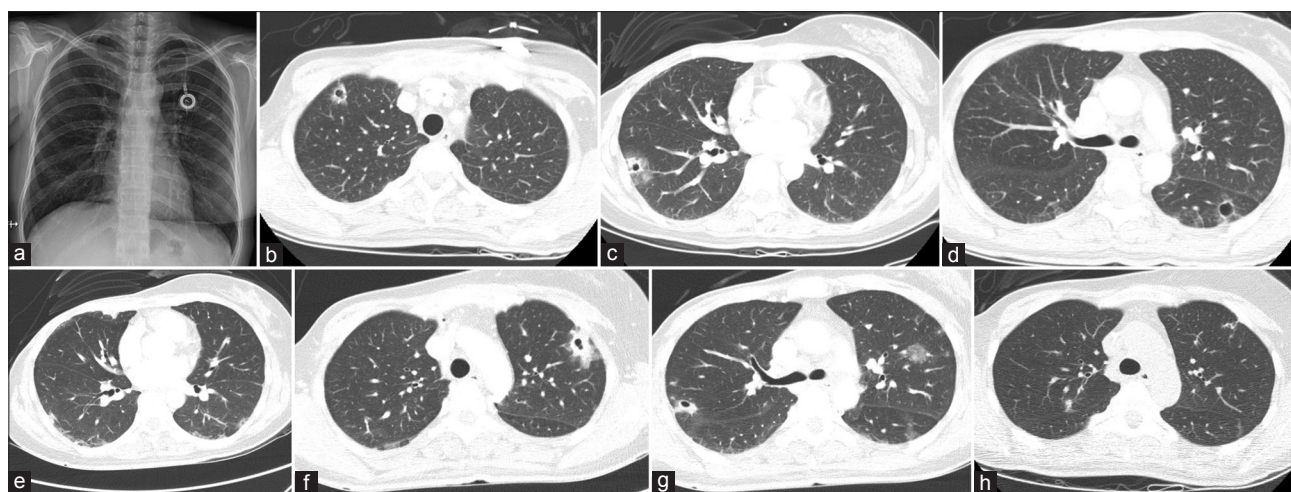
Chest radiography of this patient. (a) Initial chest radiography for the first episode of SPE. The chest radiograph revealed multifocal patchy opacities in both lungs. The CVAPD insertion site is also visible. (b-d) Initial chest CT of the first episode of SPE revealed multiple nodules associated with cavitory changes in both lungs particularly on the right upper lobe, right lower lobe, and left lower lobe. (e) On hospital day 21 of the first episode of SPE, chest CT showed the improvement in multiple nodules and cavitory formations in both lungs. (f and g) Initial chest CT of the second episode of SPE. Chest CT revealed multifocal variable-sized ill-defined nodular consolidations, some with cavitory formations, in both lungs. (h) On hospital day 21 of the second episode of SPE, chest CT showed improvement of the multifocal nodular consolidations, including those with cavity formations, in both lungs. SPE: Septic pulmonary embolism; CVAPD: Central venous access port device; CT: Computed tomography.
